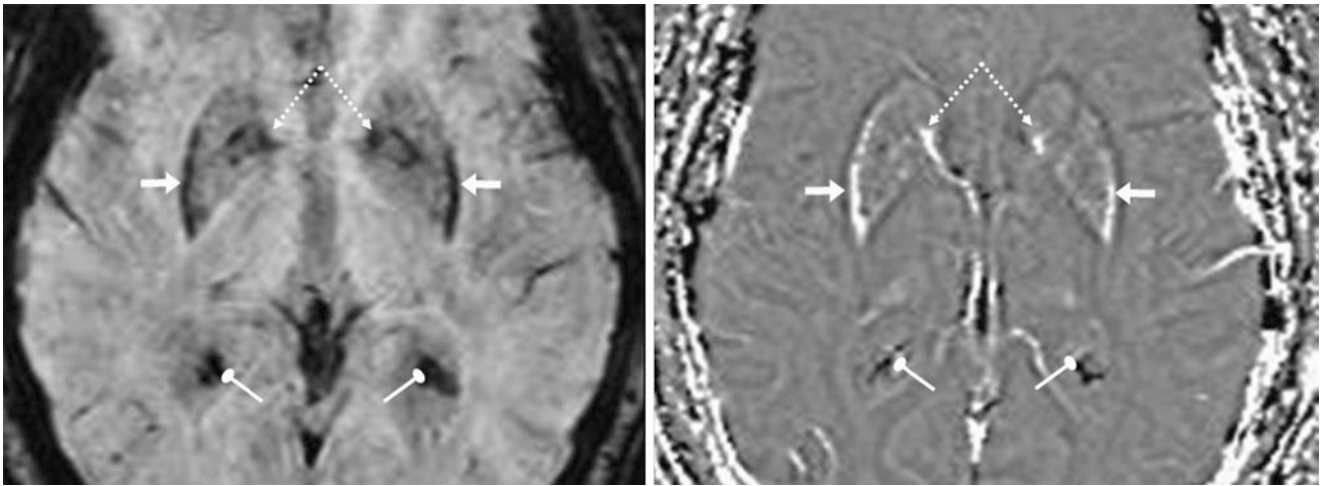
A 79 year old with a negative 1.5T MRI performed for seizures. On SWI (*left*), there is dark signal from iron deposits medially within the GP (*dotted arrows*), along with a crescent of dark signal along the lateral margin of the putamina. On a filtered phase map
